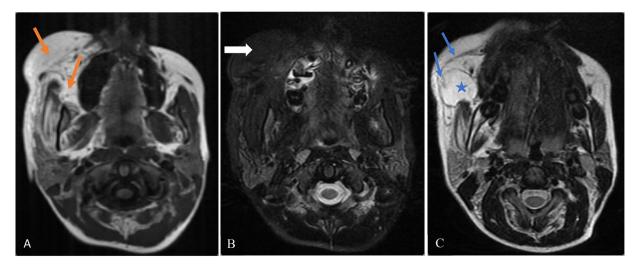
MRI images showed an infiltrative lesion in the subcutaneous, muscular and intermuscular planes of the face on the right side (orange arrow), with a moderate decrease in signal intensity on T2-weighted images (blue star), irregular linear regions of hypo intensity were also present (blue arrow). The lesion was hypointense on fat-suppressed images (white arrow).
